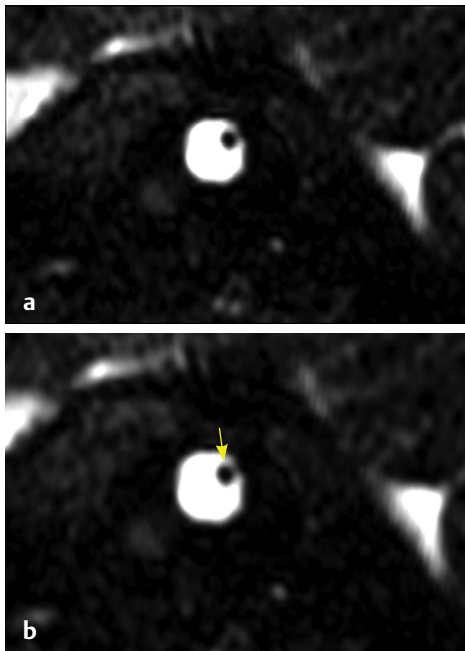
(a) MRI CISS/FIESTA sequence, oblique sagittal images at fundus of IAC and (b) show single facial nerve (yellow arrow).
